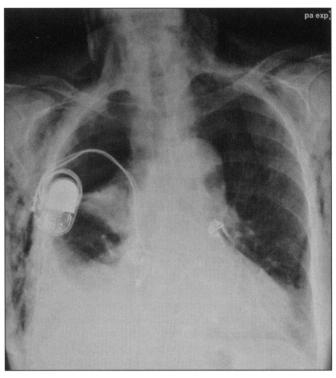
The anteroposterior view of the chest radiograph clearly shows a large right pneumothorax, which was treated with a chest tube. Subcutaneous emphysma was also noticed in four patients, with or without a pneumothorax.
